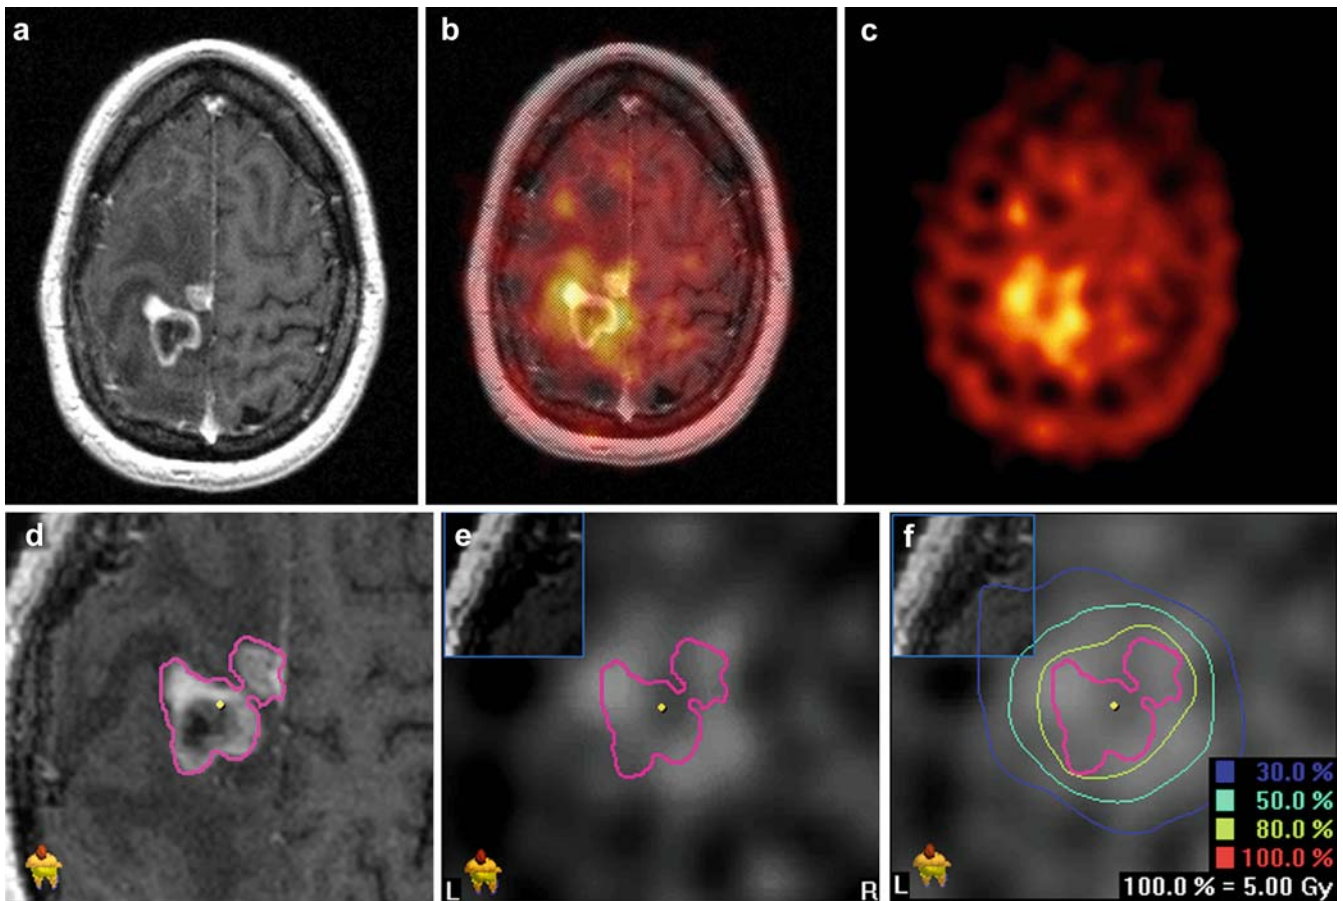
A 34-year-old female patient with a metastasis of a breast cancer presented 5 months after radiation therapy (patient no. 9). The T1-weighted MR image (a) depicted a progressive, ring-like enhancement with a nodular component, suspicious of recurrence. IMT-SPECT (c) shows a high amino acid accumulation in the lesion and suggests a larger tumour extension than the MR image does (fused image, b). If the planning target volume (PTV > 80% of isodose) is defined on the basis of MRI alone (d), significant parts of proliferating tumour are still outside of the PTV (e, f, Brain SCAN 5.1, Brain Lab AG, Heimstetten, Germany)
